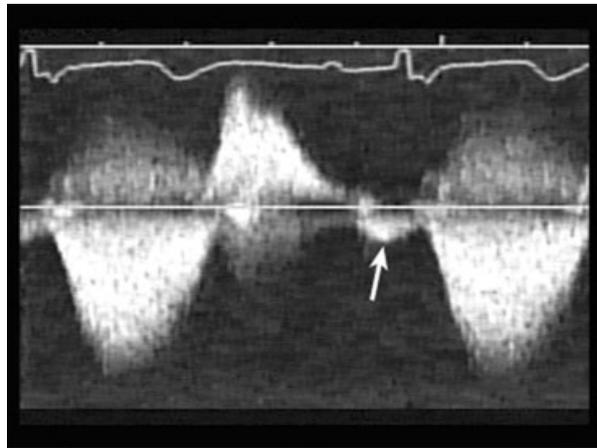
Assessment of right ventricular diastolic function in patients with pulmonary regurgitation following tetralogy of Fallot repair is an integral part of any comprehensive echocardiographic evaluation. Restrictive physiology leads to antegrade forward flow in the pulmonary artery (arrow) during atrial contraction. This should be noted during all phases of respiration and on 5 consecutive beats.
